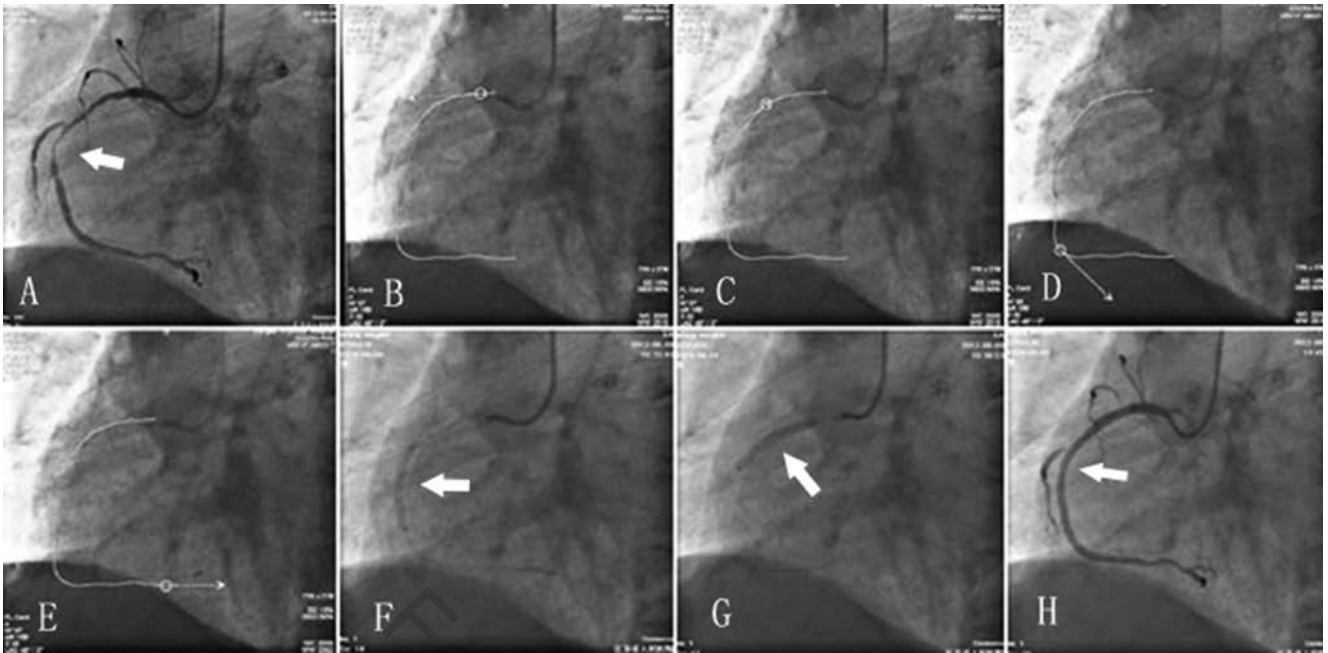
Magnetic navigation system and computed tomography (CT) roadmap-assisted percutaneous coronary intervention. (A) Right coronary angiography, arrow shows a severe stenosis in the mid-right coronary artery (RCA). (B) CT-derived roadmap (white line) projected on the x-ray screen, arrow shows the direction of the magnetic field. (C, D, E) CT-derived roadmaps (white line) projected on the x-ray screen, arrows show the changes of the direction of the magnetic field while advancing the guidewire. (F, G) Fluoro image, arrow shows the successfully deployed stents. (H) Right coronary angiography, arrow shows that the stenosis of the RCA disappeared after stent deployment.
